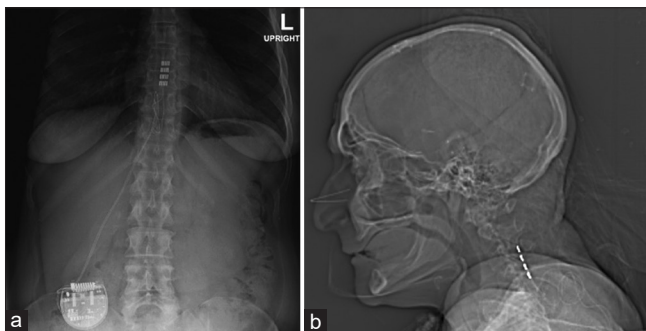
(a) Thoracic and (b) cervical X-rays of the spine showing placement of the thoracic and cervical paddle leads in patient 1.
